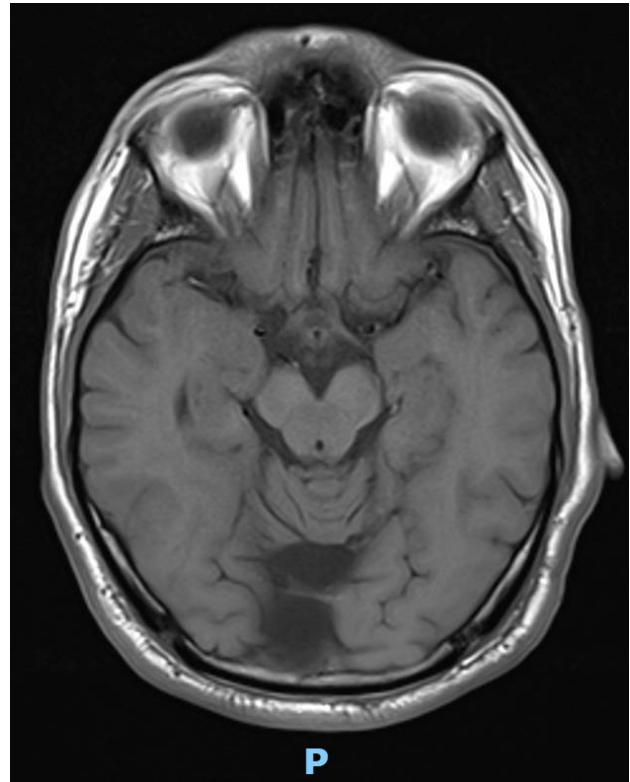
An axial MRI scan of the brain shows the contained or confined MCM affecting the occipital lobes of the brain.
